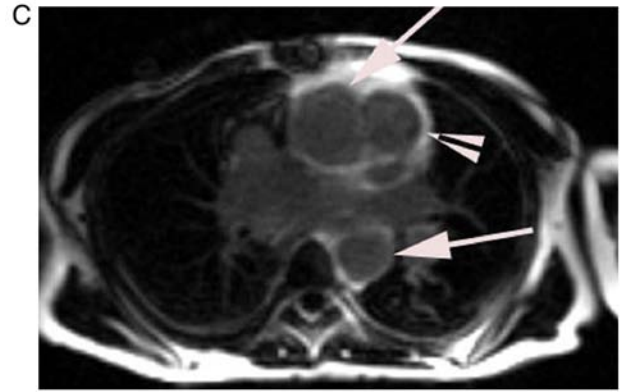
(A and B) FDG PET/CT scan and (C) MRI images of a patient diagnosed with Takayasu arteritis. (A) Coronal PET maximum intensity projection image demonstrating abnormal FDG uptake in the wall of the ascending aorta and pulmonary artery (arrows). (B) Axial fused image of FDG PET/CT confirming the abnormal FDG uptake in the ascending and descending aorta (arrow) and pulmonary artery (arrowhead). (C) Post gadolinium enhancement axial MRI at the level of the ascending aorta demonstrating abnormal wall thickening and gadolinium enhancement in the ascending aorta (arrow), and pulmonary artery wall (arrowhead). FDG, fluorodeoxyglucose; PET, positron emission tomography.
